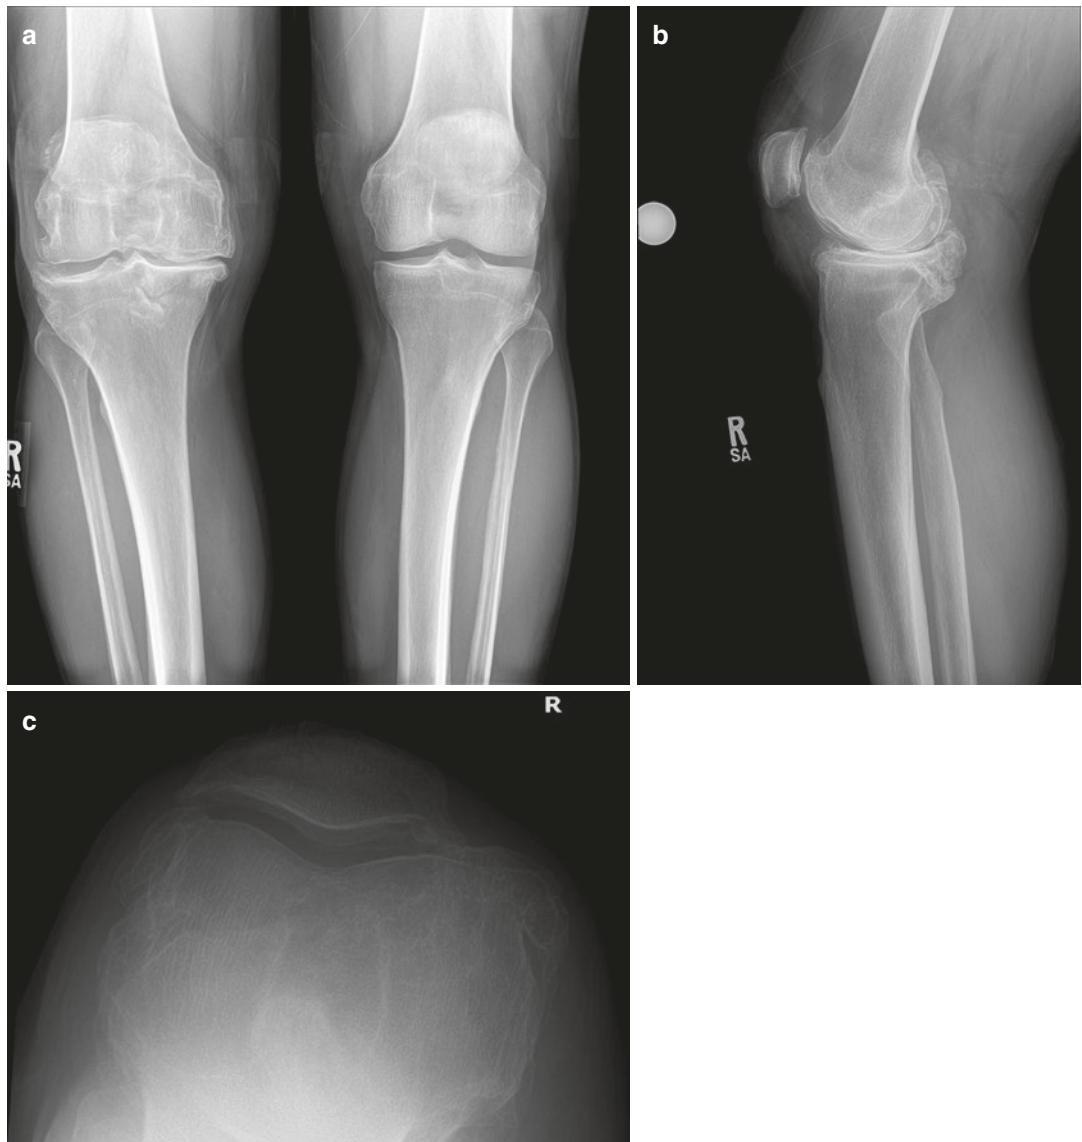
Preoperative radiographs. (a) Anteroposterior (AP), (b) lateral, and (c) sunrise obtained at the time of initial evaluation demonstrating severe degenerative joint disease of the right knee
